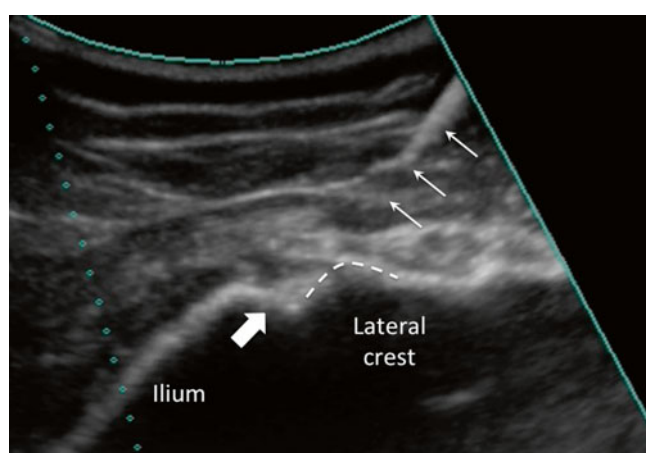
Sonography of the lower sacroiliac joint (SIJ) with the needle (*line arrows*) inserting in-plane in a medial to lateral direction. The SIJ was indicated by the bold arrow (Reproduced with permission of Philip Peng Educational Series)
